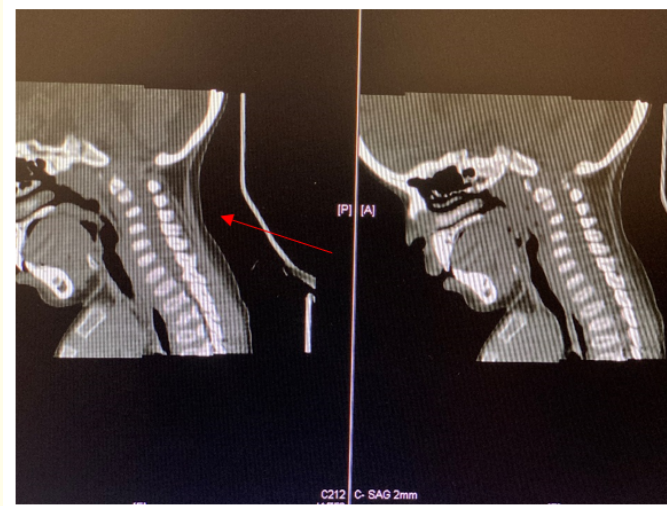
Cervical CT scan revealed flat cervical vertebra, hypoplasia of the odontoid process and the corresponding spinal canal is narrowed. Spinal stenosis in C1.
